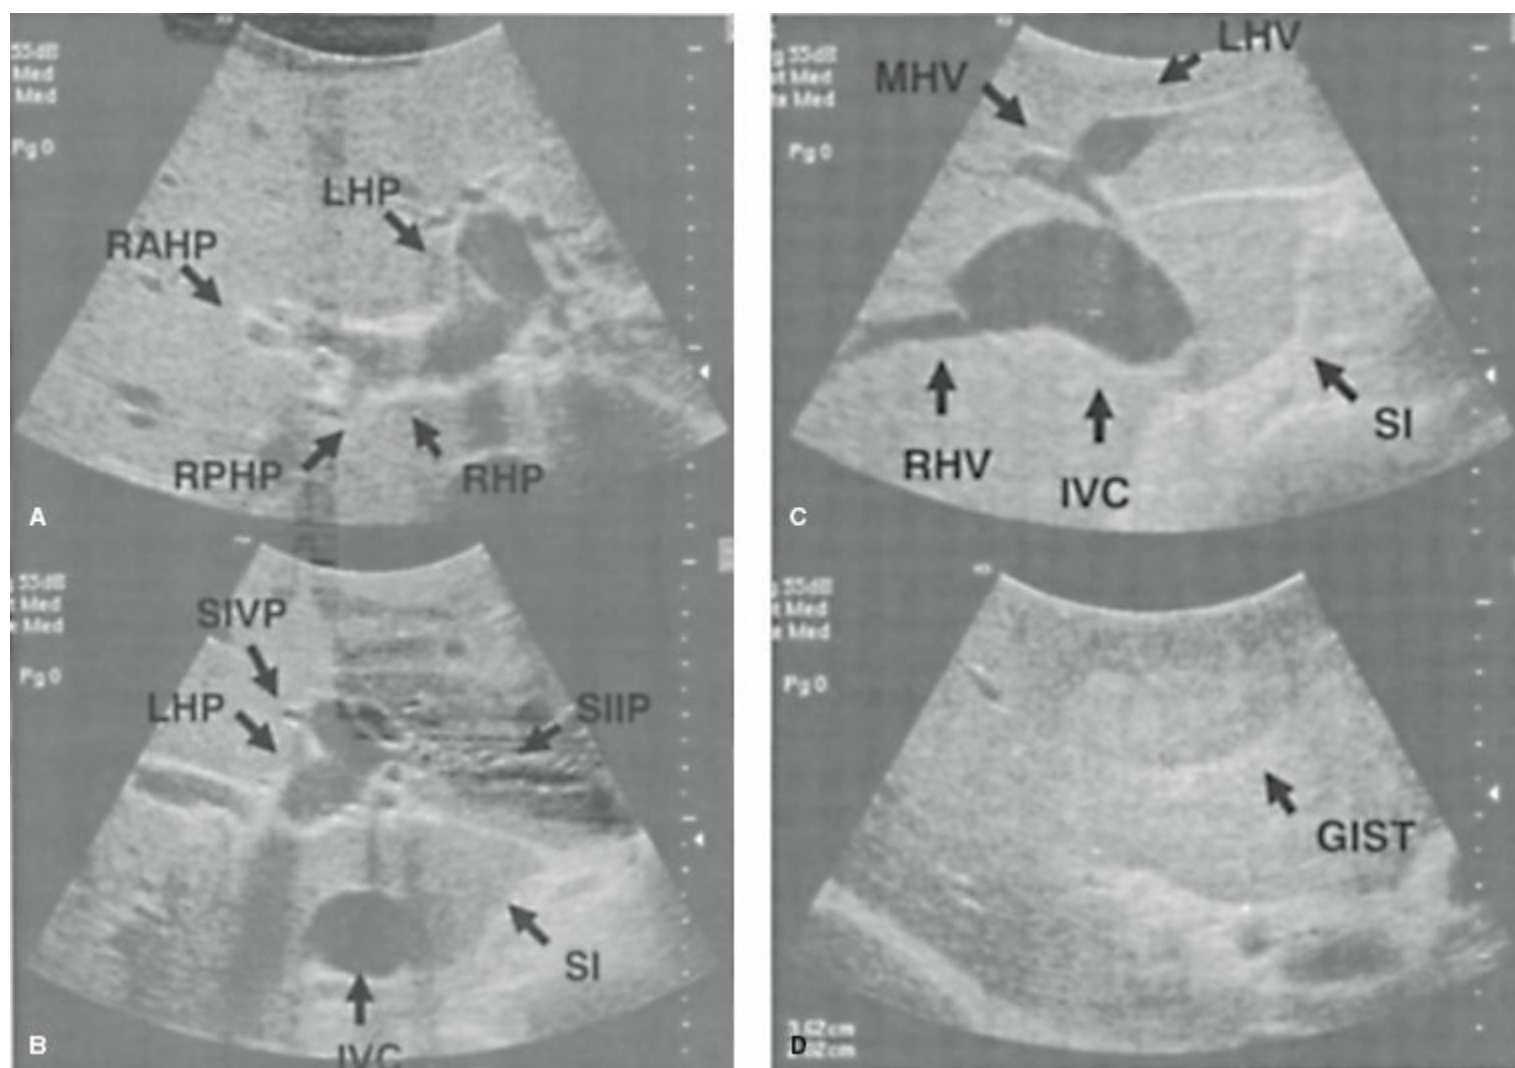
A,B: Intraoperative ultrasound images of liver demonstrating right hepatic pedicle (RHP), right anterior sector pedicle (RASP), right posterior sector pedicle (RPSP), left hepatic pedicle (LHP), segment II pedicle (SIIP), segment IV pedicle (SIVP), segment I (SI), and inferior vena cava (IVC). C,D: Intraoperative ultrasound images of liver demonstrating inferior vena cava (IVC), right hepatic vein (RHV), middle hepatic vein (MHV), left hepatic vein (LHV), segment I (SI), and a metastatic gastrointestinal stromal tumor lesion straddling segments IV and V of the liver.
